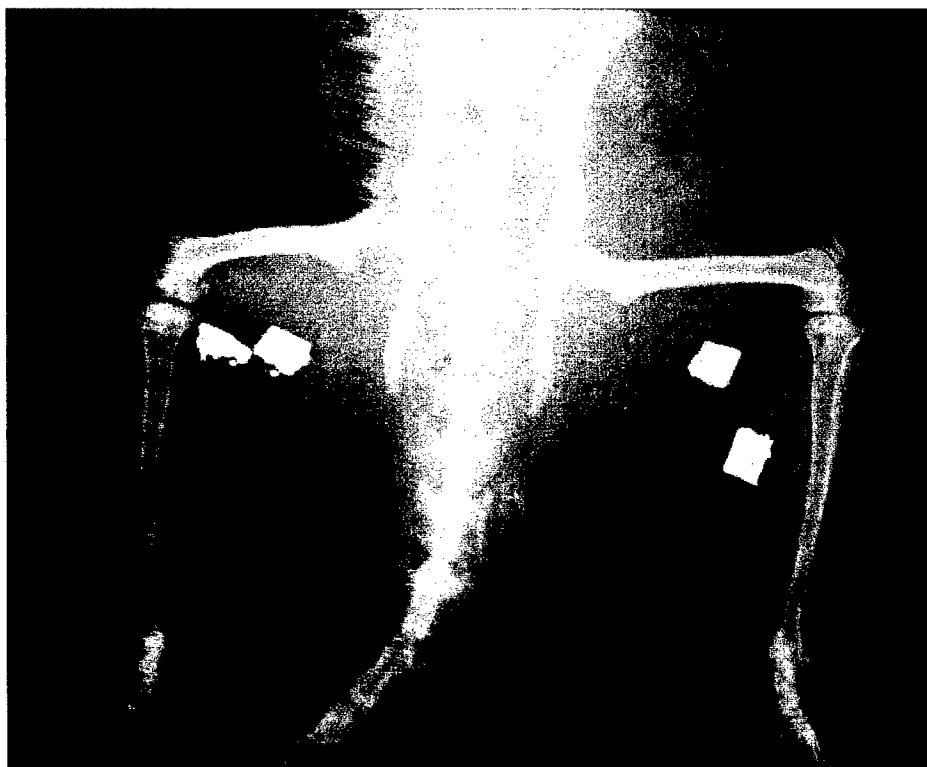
Radiograph of 5.0 x 5.0 x 1.5 mm DU(Ti) fragments 3 weeks after implantation.
